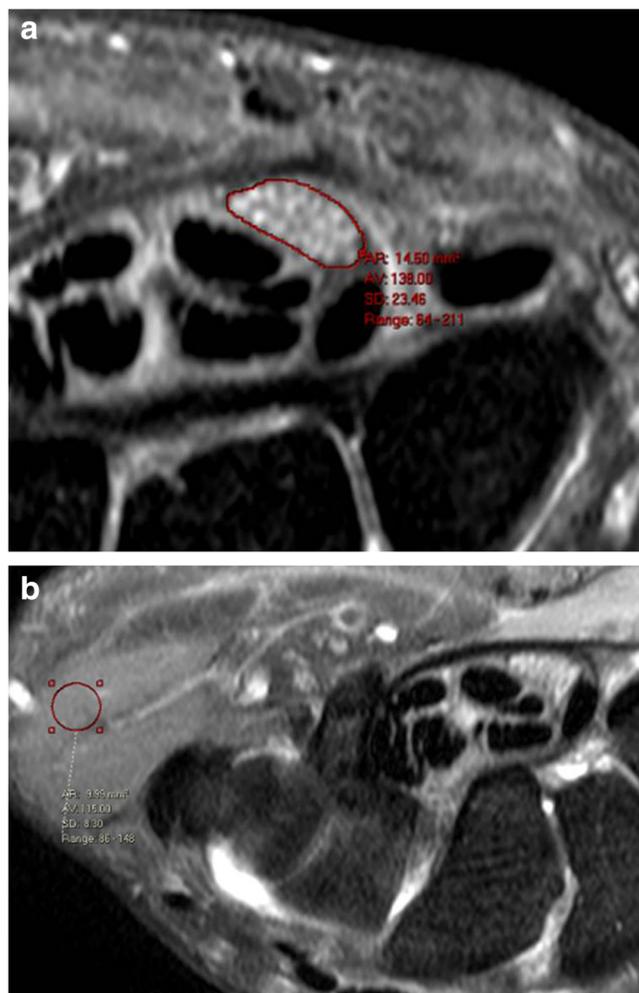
a Proton density fat-saturated axial MR image of a 46-year-old woman with CTS proximal to the carpal tunnel. The median nerve shows T2 hyperintensity of the swollen nerve fibers. The average SI of the nerve measures 138.00. b Proton density fat-saturated axial MR image of the same CTS patient at the carpal tunnel outlet. The ROI is placed in the hypothenar muscle and the average SI used as a reference to calculate relative median nerve SI. In this case, the median nerve has increased relative SI at 1.20
